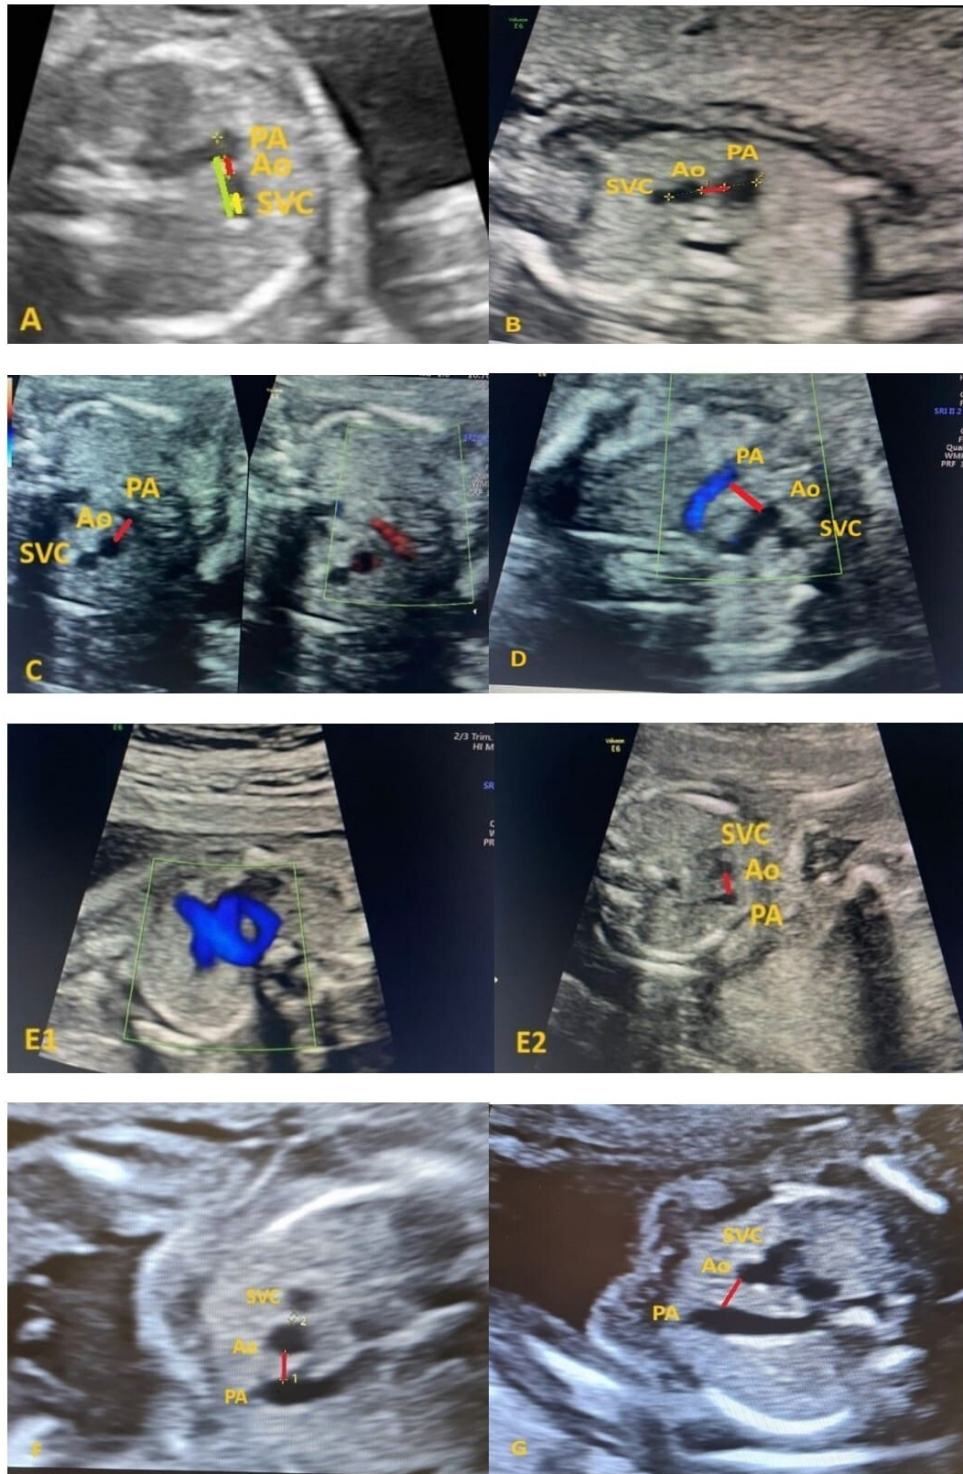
Representation of 3-vessel views in the fetal echocardiographic examination of all cases included in the study. (A) Demonstration of the distance measurements between vessels in the three-vessel view during fetal echocardiography in a fetus without anomalies [13]. (B) Case 1, a 20^{+1} weeks fetus with a RAA anomaly. (C) Case 2, 20^{+2} weeks fetus with a RAA anomaly. (D) Case 3, 19^{+2} weeks fetus with a RAA anomaly. (E1) Case 4, 20^{+2} weeks fetus with a DAA anomaly shown with color Doppler. (E2) Case 4, 20^{+2} weeks fetus with a DAA anomaly shown in the three-vessel view. (F) Case 5, 20^{+5} weeks fetus with a RAA anomaly. (G) Case 6, 19^{+1} weeks fetus with a RAA anomaly. PA, pulmonary artery diameter; Ao, aortic diameter; SVC, vena cava superior diameter; RAA, right aortic arch; DAA, double aortic arch. Red line, distance between PA and Ao; yellow line, distance between Ao and SVC; green line, distance between PA and SVC.
